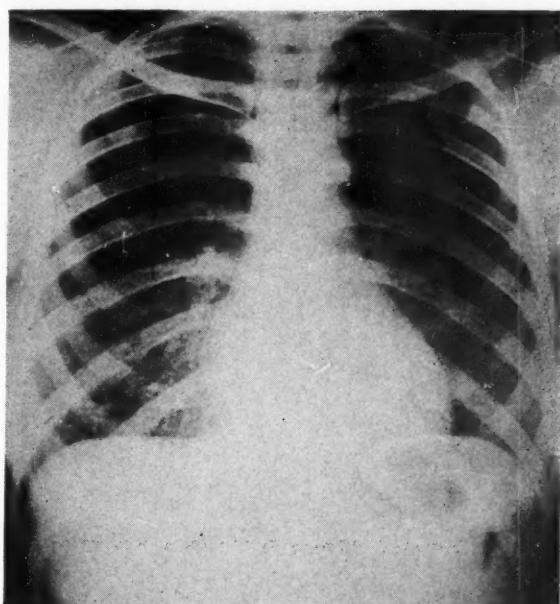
Chest roentgenogram showing bilateral miliary densities.
